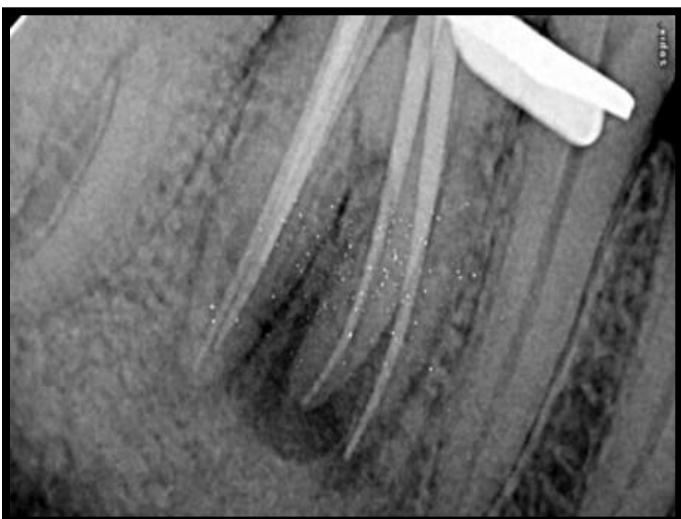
master cone radiograph
